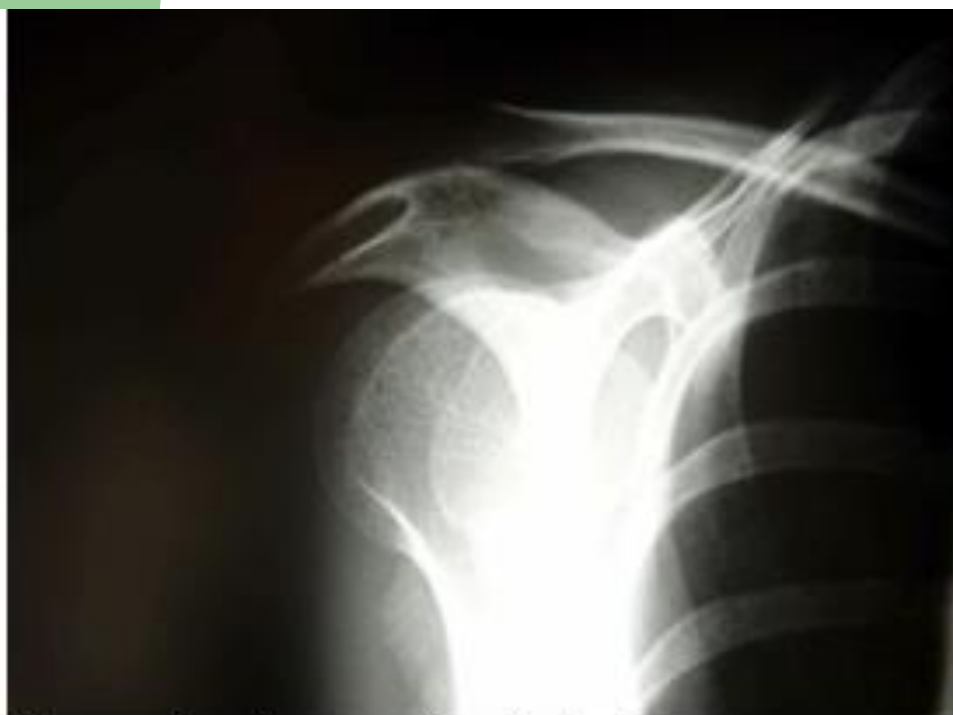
A normal outlet view x-ray
